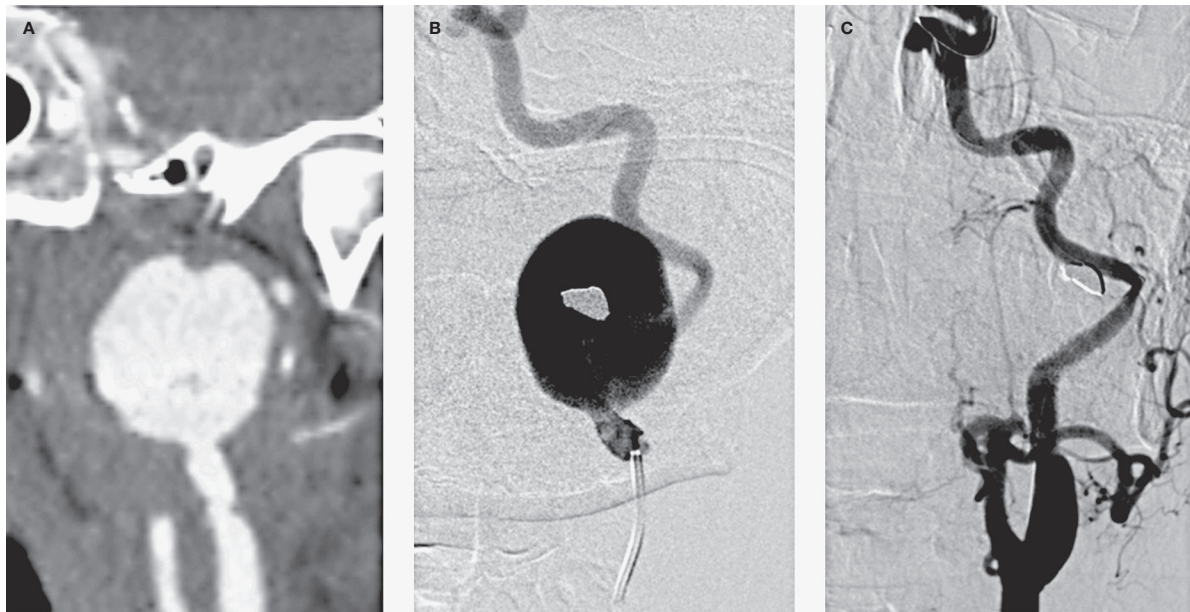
CTA (A) and DSA (B) of a giant false aneurysm of the cervical segment of the left ICA and post-procedure angiography after placement of a covered stent (C).
